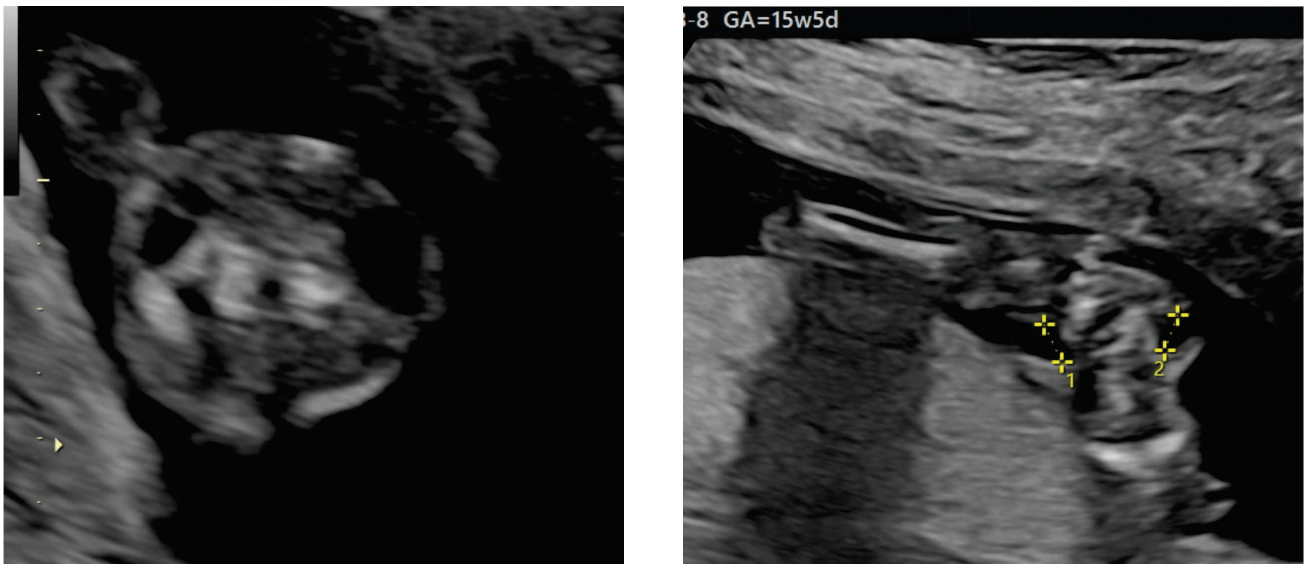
Ultrasonographic image of fetal neck in transverse section at 15 weeks and 5 days, showing a decrease in anterolateral cervical cysts diameter to 5.10 mm and respectively 4.60 mm
